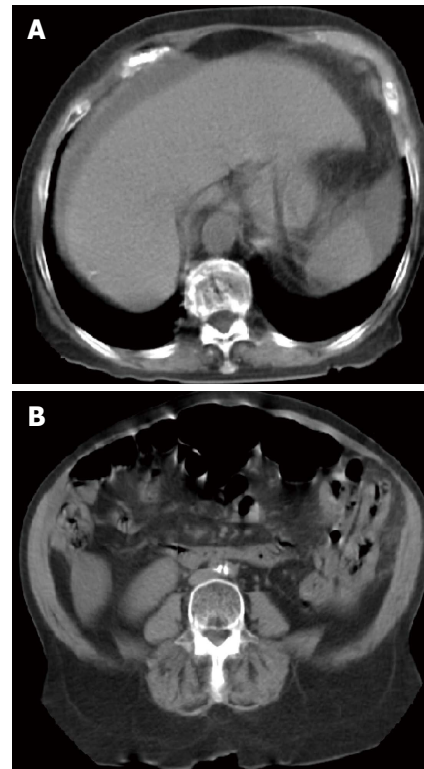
Computed tomography of the abdomen and pelvis showing massive ascites and normal-sized liver and spleen.
